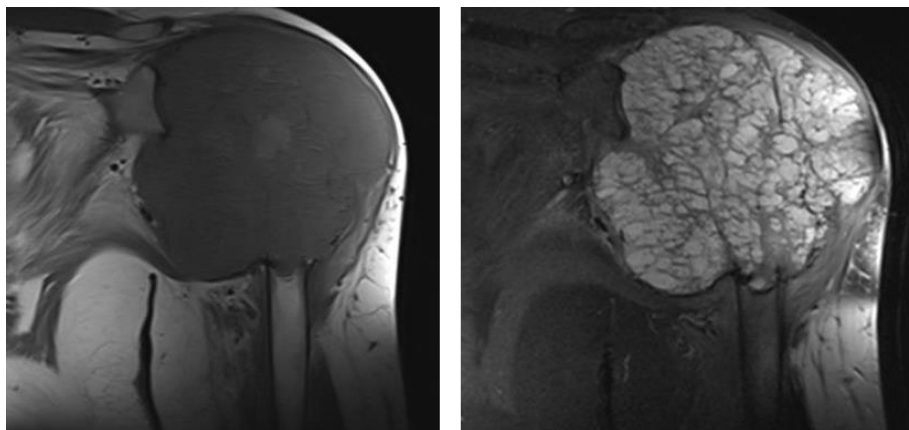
Giant cell tumor: MRI T1W coronal and T2 FSI images reveals large multiloculated cystic lesion in the proximal left humerus with narrow zone of transition. The locules of the lesion show multiple fluid filled levels. It is hypointense on T1WI and hyperintense on T2WI
